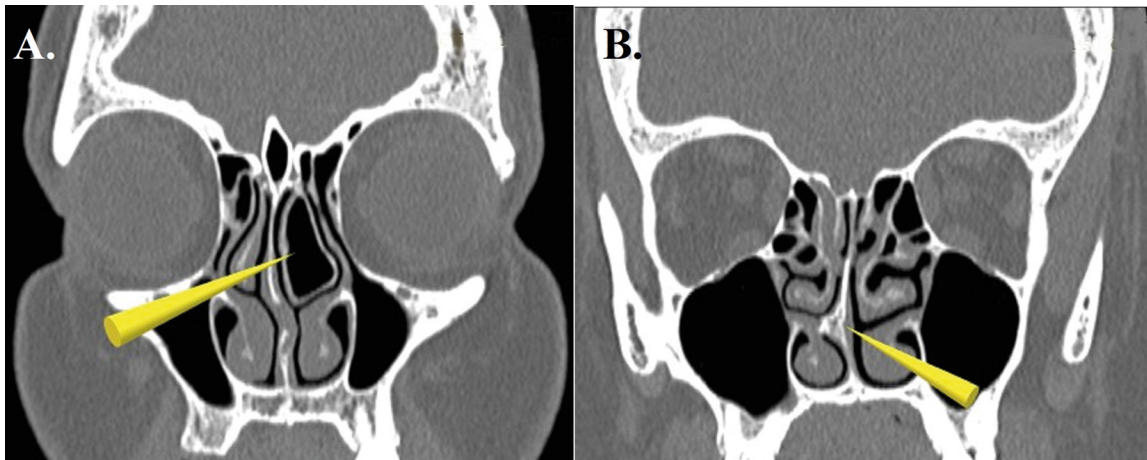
Computed tomography. (A) Concha bullosa – the air cell forms the shaft of the nasal turbinate. (B) The nasal septum spike touches the medial surface of the lower right nasal turbinate.
